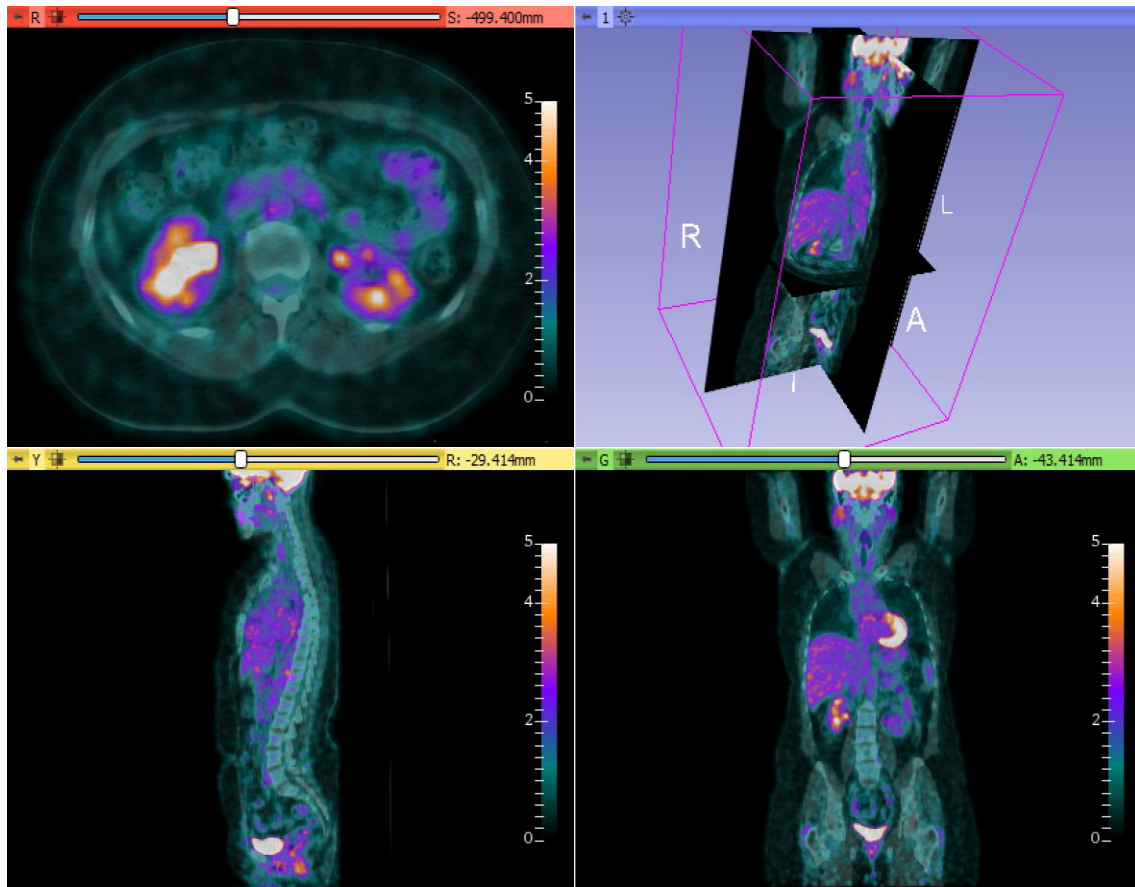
Representative axial, coronal and sagittal slices of a PET/CT image of the same patient in the software 3D Slicer. The color map used is similar to the one used in the Nuclear Medicine Department daily.
